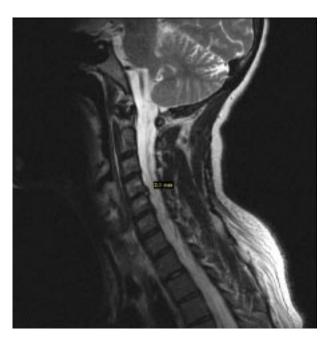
Magnetic resonance imaging of the cervical spine revealed multiple osteophytes and mild disk protrusions at C4 through C7.
